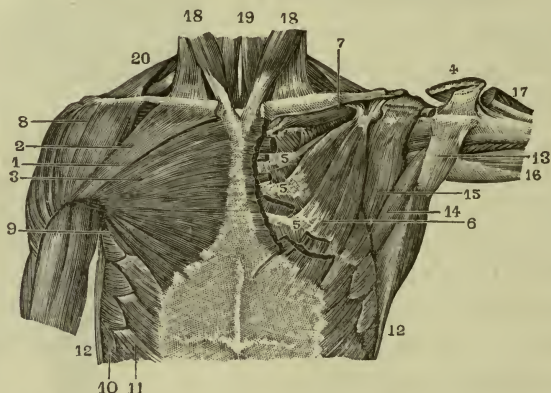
MUSCLES OF ANTERIOR ASPECT OF THORAX.
